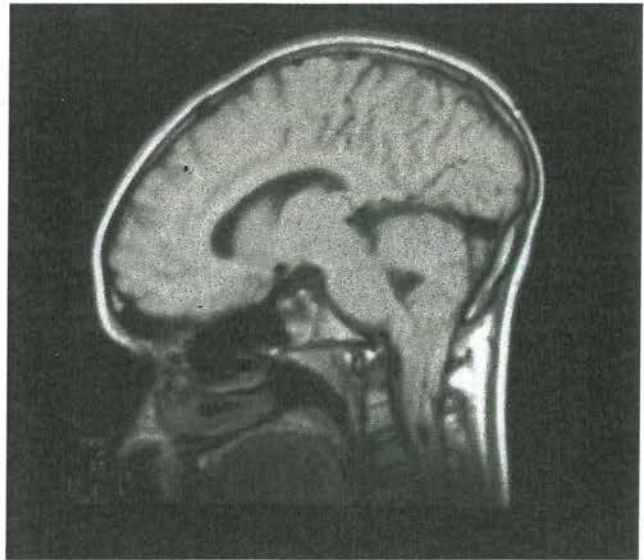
Sagittal T1-weighted MRI scan of Arnold-Chiari malformation
